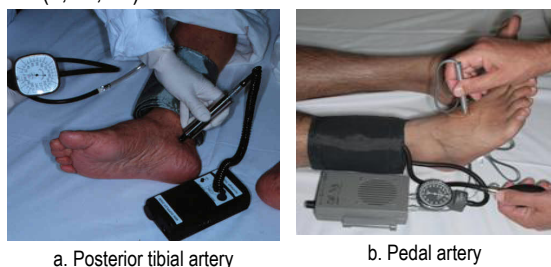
Technique for measuring blood pressure with Doppler probe
